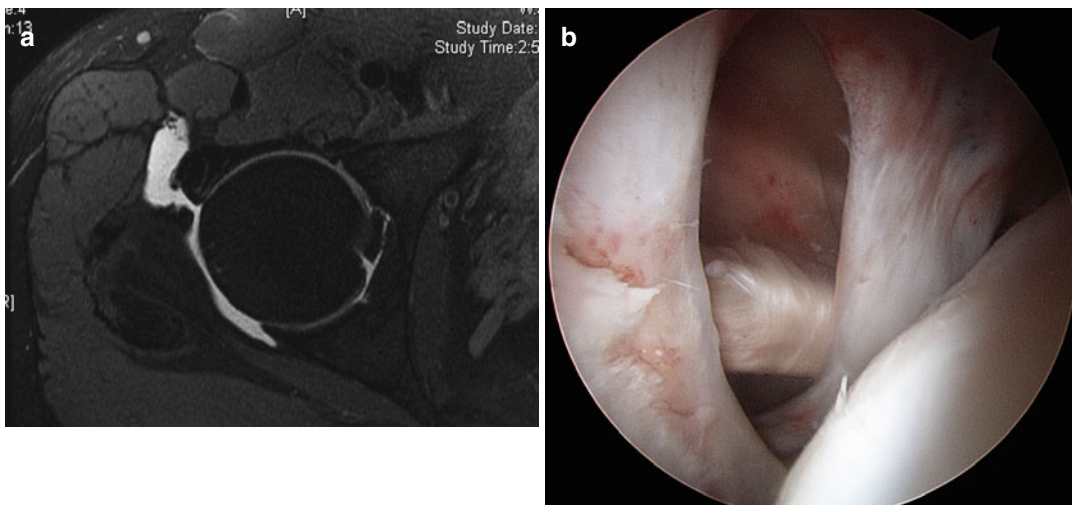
MRI (a) of an extensive capsulotomy resulting in symptomatic microinstability. Primary capsular closure may be performed, as in this case. Alternatively, capsular plication may be performed through the interval
